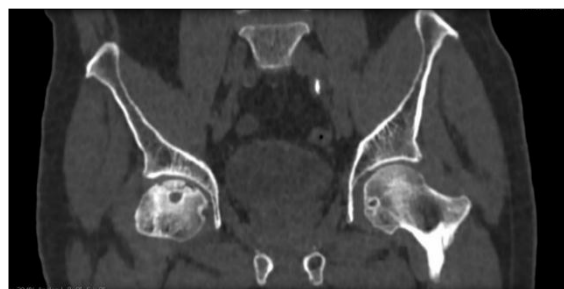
CT-coronal: irregular and flattening of the anterosuperior femoral head contour on the right side
